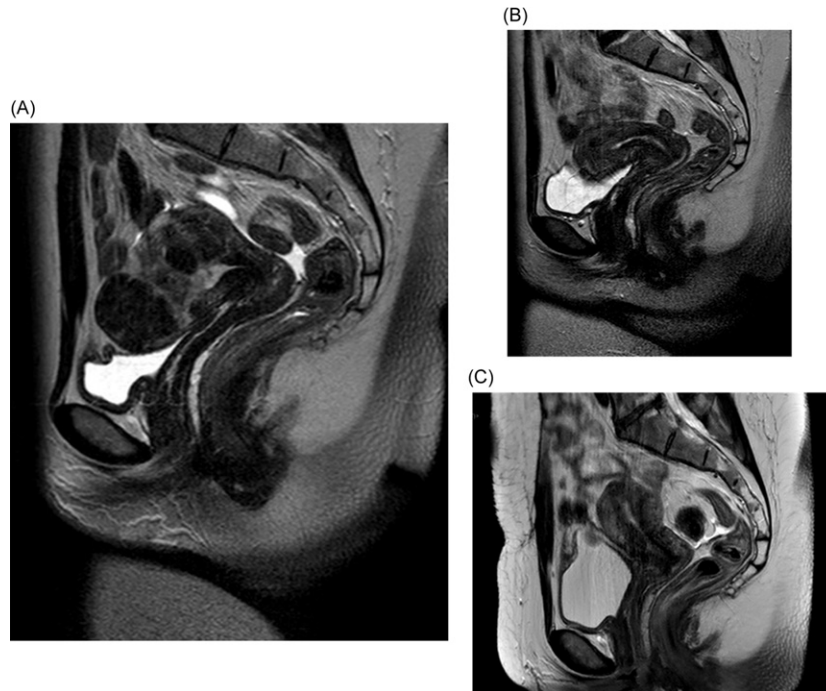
Considerable shrinkage of all myomas after four courses of intermittent ulipristal acetate (UPA) therapy. A patient aged 30 years presented with heavy menstrual bleeding and an unclear desire for pregnancy. (A) Before treatment, a midline sagittal T2-weighted magnetic resonance image (MRI) demonstrated the presence of multiple myomas: types 2, 3, 4, and 6. (B) Upon completion of treatment (intermittent UPA therapy (four courses of 3 months), the uterine cavity was no longer distorted. (C) One year after delivery of a healthy baby, no fibroid regrowth was observed after delivery. Adapted from Donnez, J. and Dolmans, M. M. (2016). Uterine fibroid management: From the present to the future. *Human Reproduction Update* 22, 665–686; Donnez, J., Donnez, O., Matule, D., Ahrendt, H. J., Hudecek, R., Zatik, J., Kasilovskiene, Z., Dumitrascu, M. C., Fernandez, H., Barlow, D. H., *et al.* (2016). Long-term medical management of uterine fibroids with ulipristal acetate. *Fertility and Sterility* 105, 165–173.
